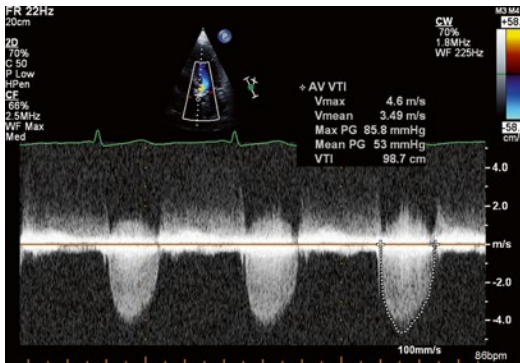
Continuous wave Doppler spectral recording from the left ventricular apex demonstrating method of measurement in order to obtain peak and mean velocities. The spectral envelope should be traced at the clearly defined edges and without including any low intensity signals, if present
